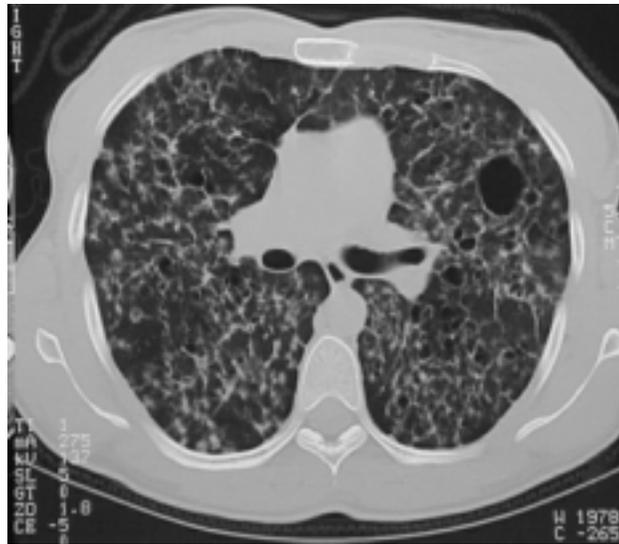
High resolution computed tomography of the lung; December 1998, without any treatment.
